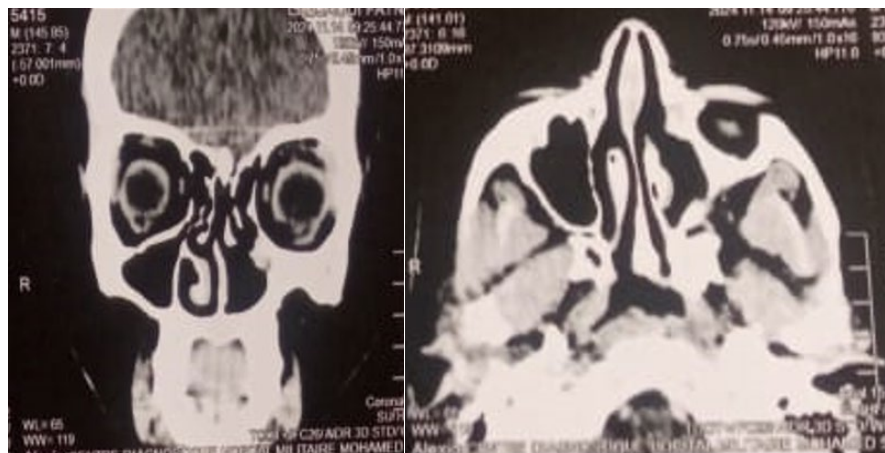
Coronal and axial CT scan showing no recurrence after two years of follow up.
